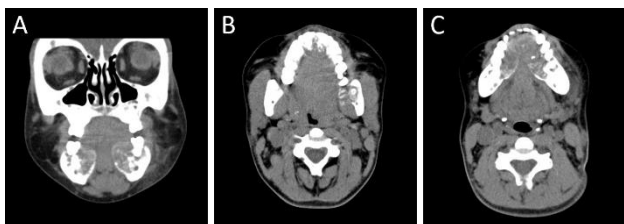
Coronal (A) and axial (B,C) sections of a cranio-facial computed tomography scan without radiocontrast agent showing hypodense intraosseous lesions on medial surface of posterior mandible (A), anterior hard palate and left mandibular ramus (B) in addition to lingual aspect of mandibular body (C).
